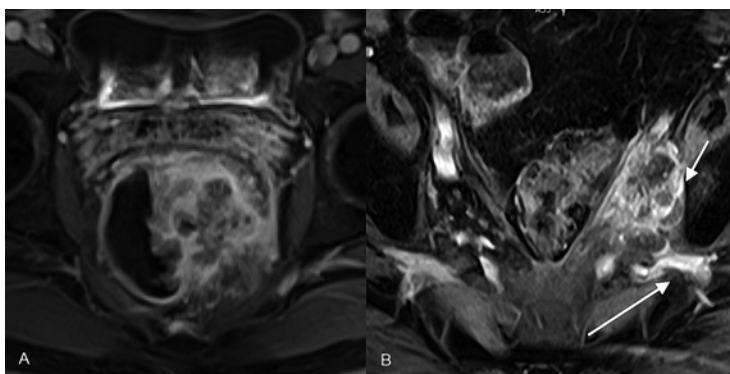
Post-contrast T1-weighted axial MRI images showing (a) direct tumor extension of tumor into the mesorectal fat and inflammation extending to the pelvic sidewall. Recurrent adenocarcinoma (b) involving the pelvic sidewall to the hypointense cortical bone (*short arrow*) without extension into the greater sciatic notch (*long arrow*)
